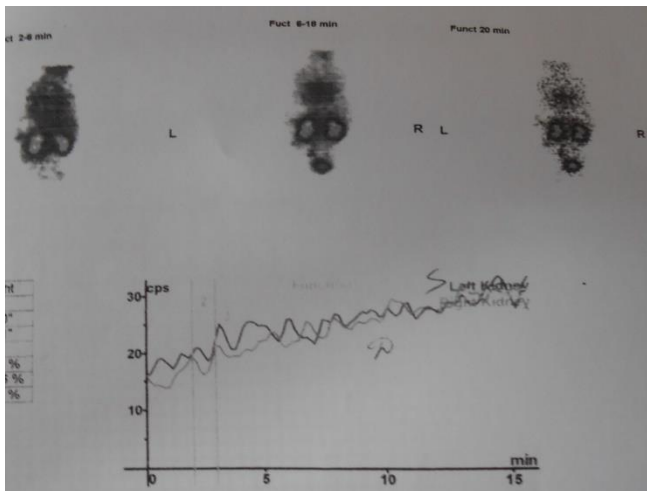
Dynamic renal scintigraphy, marked voiding dysfunction in a child with bilateral reflux.
